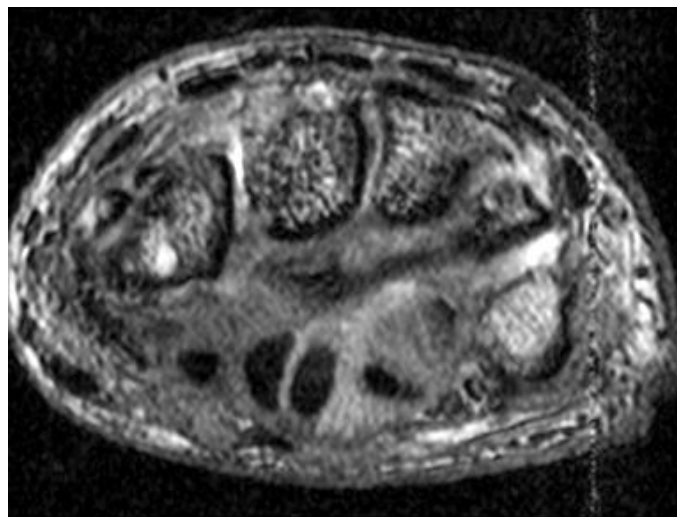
An axial MR image affected by the magic-angle effect. The signal intensity of the tendons on the right side of the carpal tunnel has increased to a similar intensity as that of the surrounding tissue.
